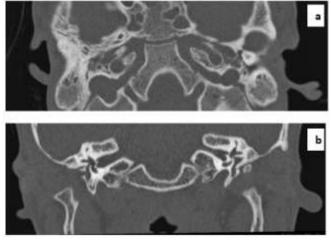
axial (a) and coronal (b) HRCT images shows complete b/l EAC atresia. Also note presence of small and deformed pinna
